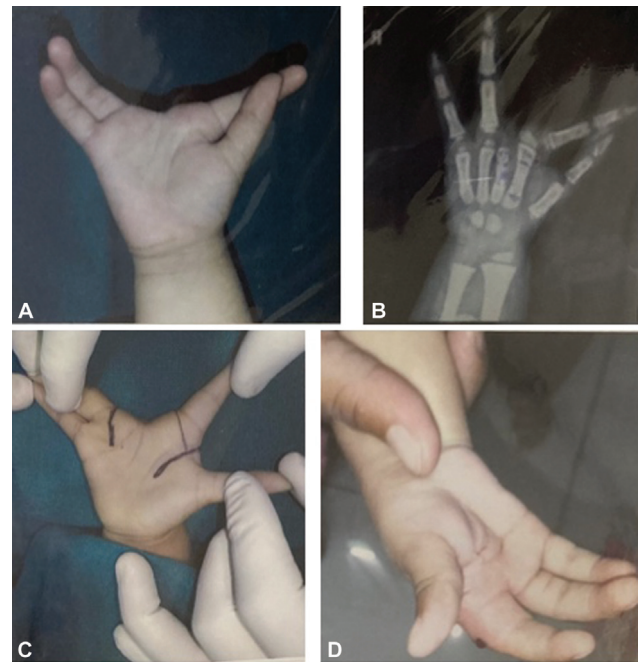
(A) Preoperative photograph and (B) preoperative radiograph for case 2. (C) Intraoperative photograph with incisions marked and (D) final postoperative photograph at 6 months.
